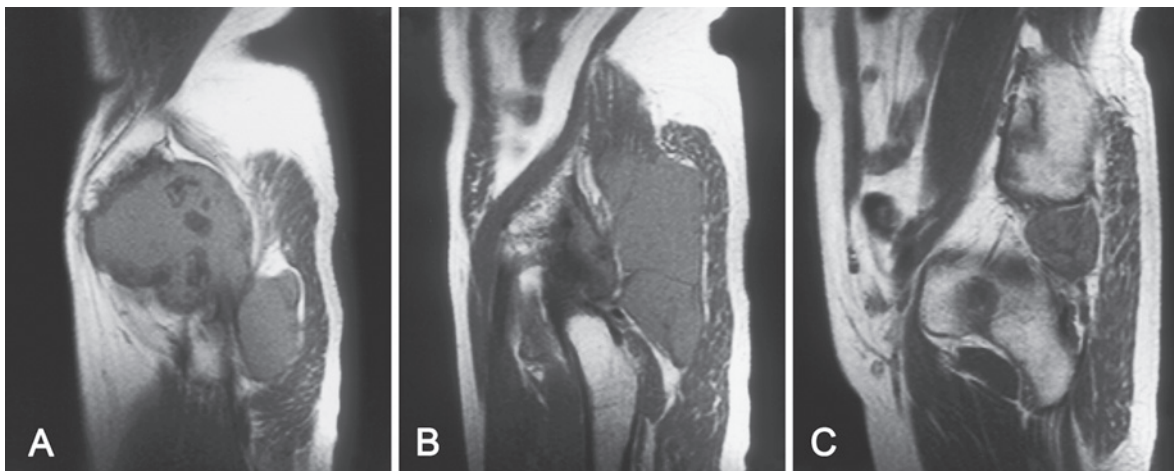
A–C: T1-weighted sagittal magnetic resonance images demonstrating a cystic lesion involving the gluteus medius, gluteus minimus, and piriformis muscles. (A) Plane including the greater trochanter of the femur. (B) Plane including the lesser trochanter of the femur. (C) Plane including the greater sciatic foramen.
